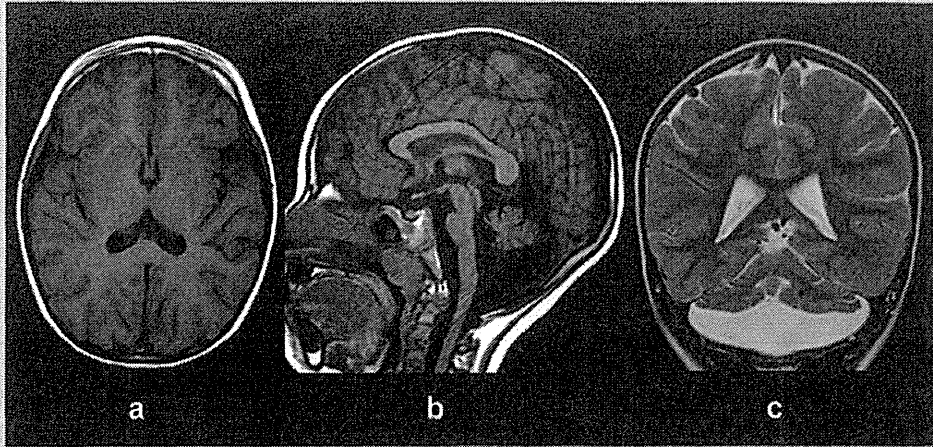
Axial (a), mid-sagittal (b), and coronal MRI (c) of a 50-month-old female with *CASK* mutation (Patient 11). Note the microcephaly (a), hypoplastic pons (b), cerebellar hemispheres (c) and vermis (b) with normal appearance of the corpus callosum (a,b).
